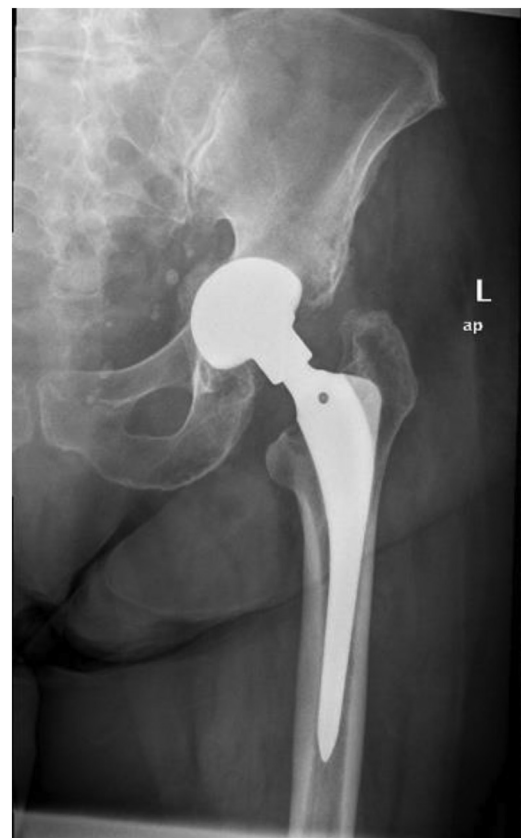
Anteroposterior radiograph of the left hip at 1-month follow-up after conversion to a total hip arthroplasty.
